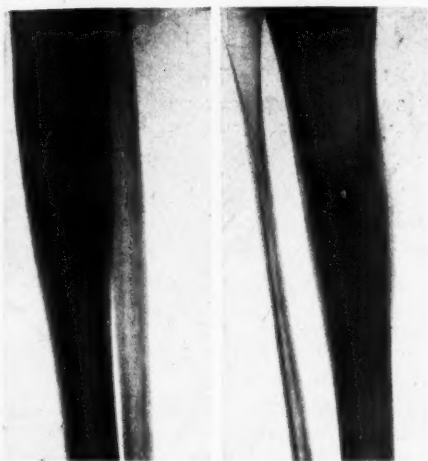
The typical roentgenologic appearance of Ewing's sarcoma. There is expansion of the shaft of the bone, produced by thickening of the cortex which is reacting to tumor invasion. This is an early stage of the disease.
